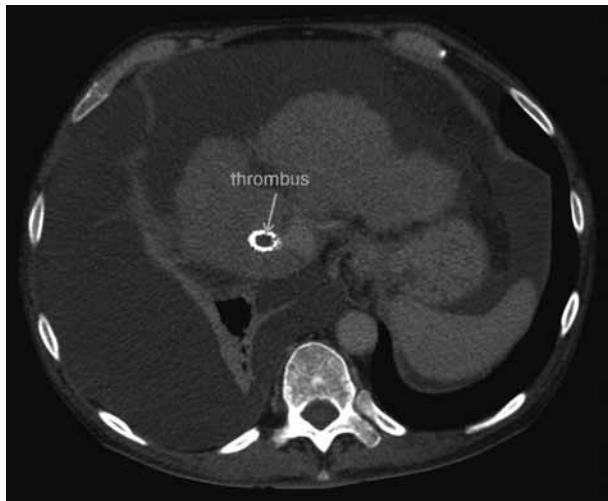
Abdominal CT showing a thrombus of the TIPS
